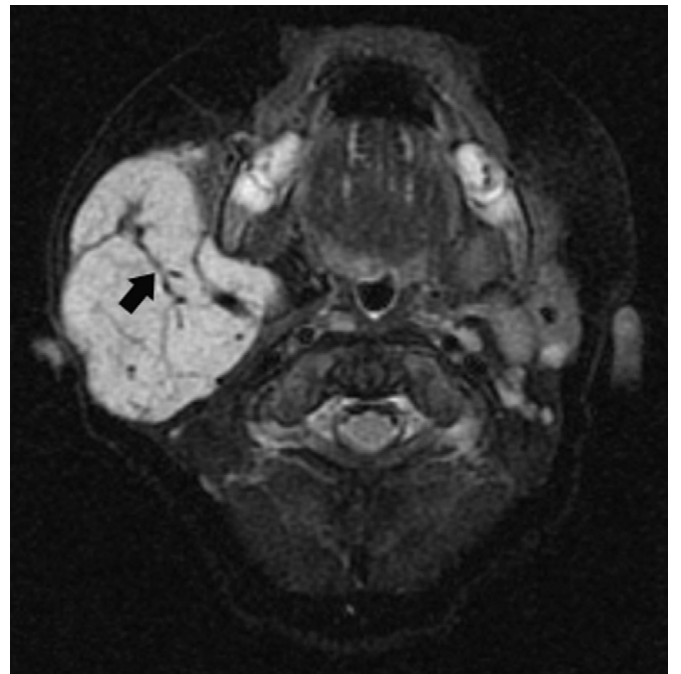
Magnetic resonance imaging (MRI) of infantile hemangioma (IH). Axial T2 weighted fat-saturation MRI sequence of a parotid IH, which shows a well-circumscribed, uniformly hyperintense mass with dilated feeding and draining vessels (*arrow*).
